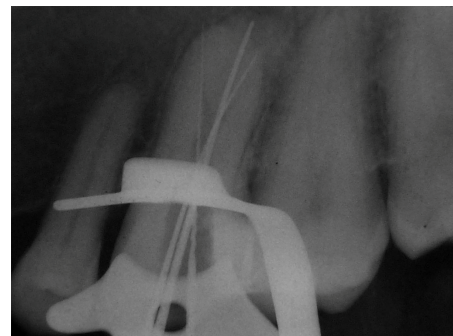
IOPA radiograph showing three root canal orifices where apex locator was used to determine the working length.
